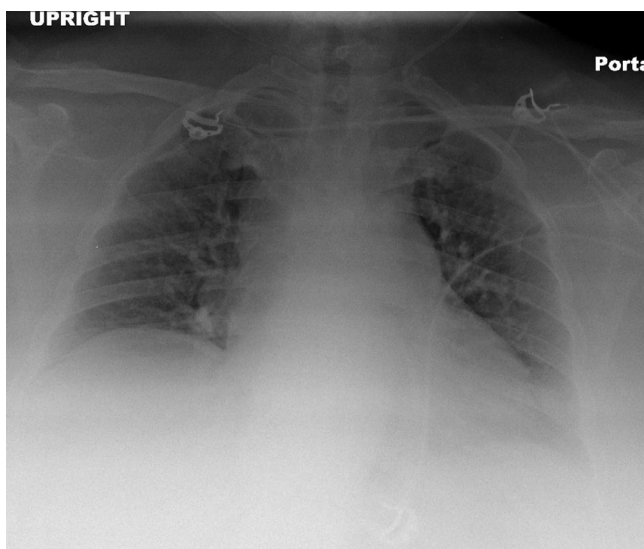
Initial anteroposterior chest x-ray shows no infiltrate and no definite pneumothorax.
